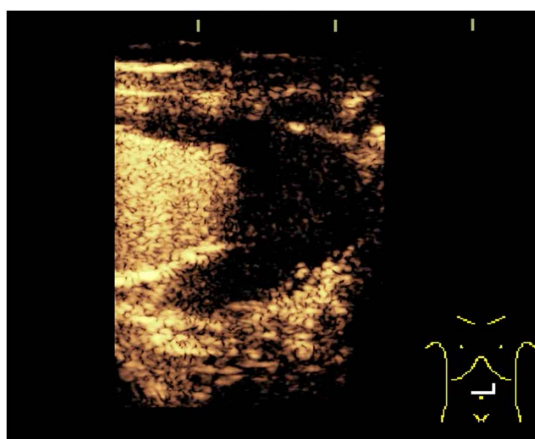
Contrast-enhanced ultrasound image of the slow endoleak case at 30s after injection of the contrast material. No contrast material is visualized in the aneurysm except in the stent graft.
